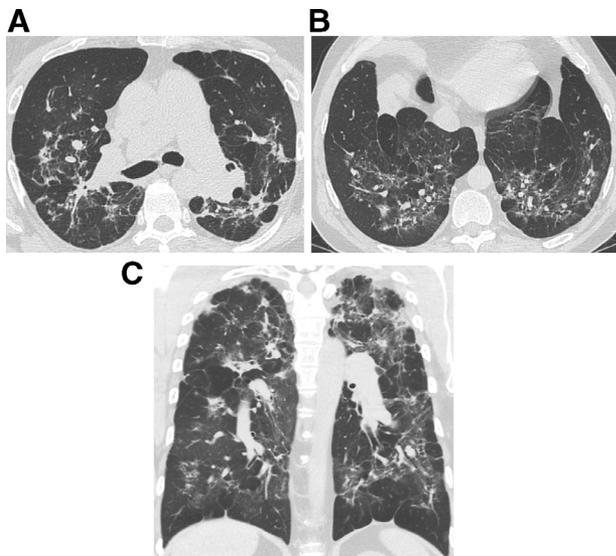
Axial (A, B) and coronal (C) images from HRCT demonstrate axially peribronchovascular and upper lung predominant reticulation, traction bronchiectasis, architectural distortion, and mosaic attenuation, most consistent with a non-IPF diagnosis (formerly inconsistent with UIP). Overall, findings are most consistent with fibrotic sarcoidosis, which was proven on pathology.
